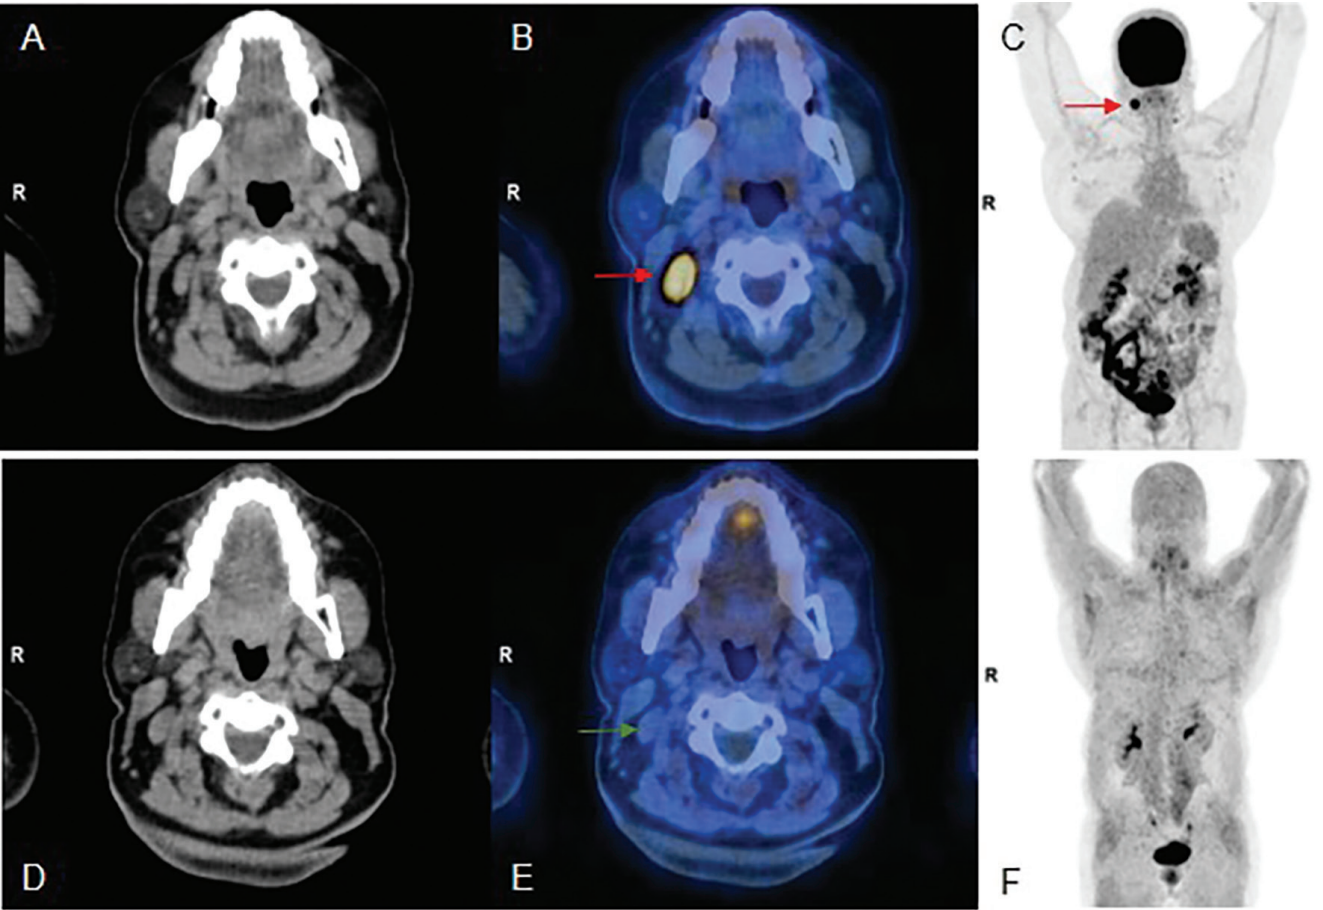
Superior lymphnodal detectability of ¹⁸F-FDG PET. (A, D) axial non contrast CT showing an enlarged right level II cervical lymph node (B, E) selected axial fused images demonstrating ¹⁸F-FDG positive node (red arrow) that was ⁶⁸Ga-FAPI negative (green arrow). (C, F) MIP images of ¹⁸F-FDG PET and ⁶⁸Ga-FAPI PET Whole body PET showing focal increased ¹⁸F-FDG in lower neck with no ⁶⁸Ga-FAPI positivity and physiological tracer distribution in rest of the whole body
